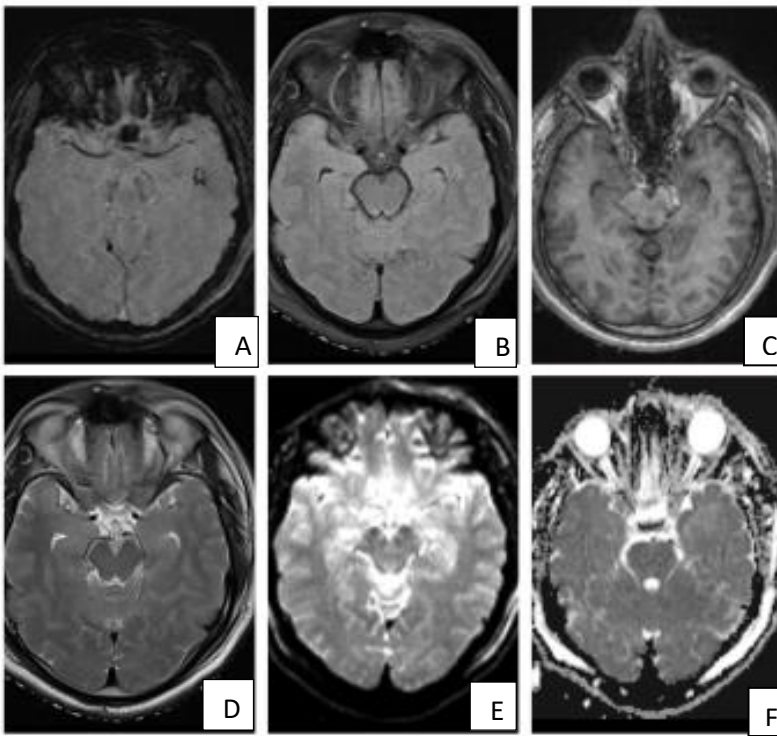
SWI image (A) showing few small focal hemorrhagic lesions in left temporal lobe of a 33-year-old male patient. Subtle hyperintensities in FLAIR image (B). Lesion not apparent on T1 (C), T2 (D), DWI (E/F)
